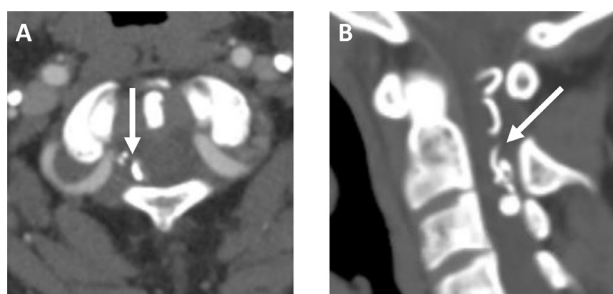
(A, B) Axial and sagittal postcontrast neck computed tomography angiography demonstrates successful occlusion of the arteriovenous fistula with radio dense embolization material (arrow).
